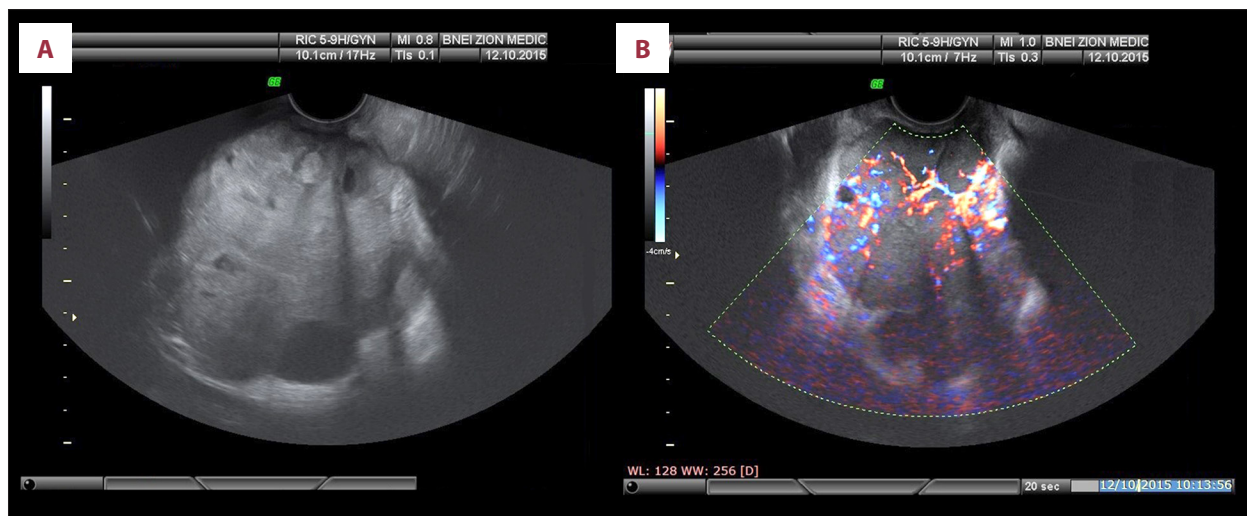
Pelvic ultrasound imaging. (A) The image shows an irregular solid mass with some cystic areas, measuring 8×9.5cm. (B) The same solid mass, imaged with color Doppler, demonstrates an abundant vascular blood flow.
